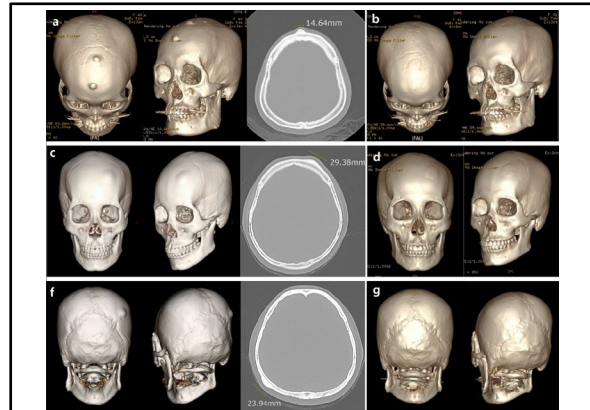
Three-dimensional and axial head computed tomography of peripheral craniofacial osteomas.
